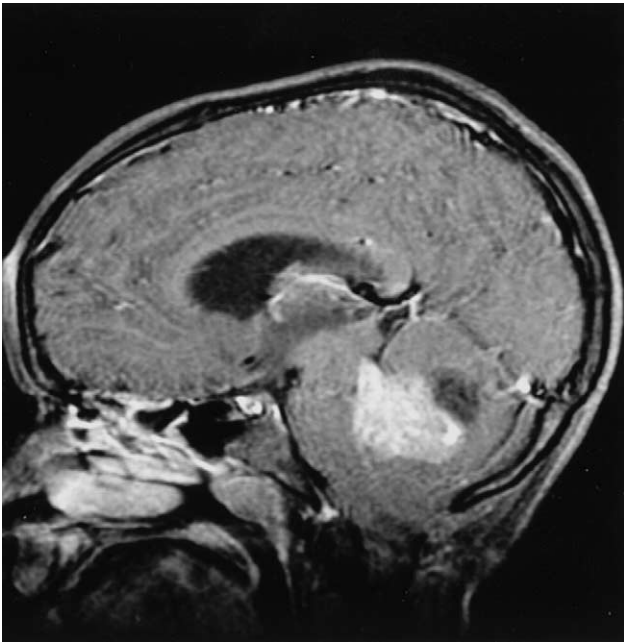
Sagittal T_1 -weighted magnetic resonance imaging with contrast (TR 467 ms, TE 14 ms). Large enhancing mass is observed in the midline cerebellum, with resultant hydrocephalus and brainstem deformation.
